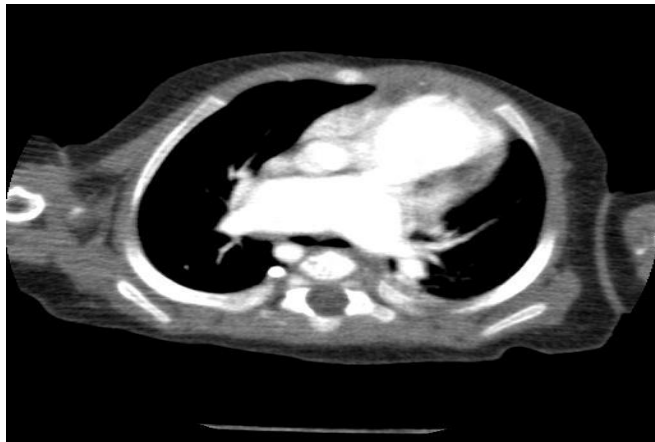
Torax CT image showing the compression of enlarged pulmonary arteries on the pulmonary bronchi.
